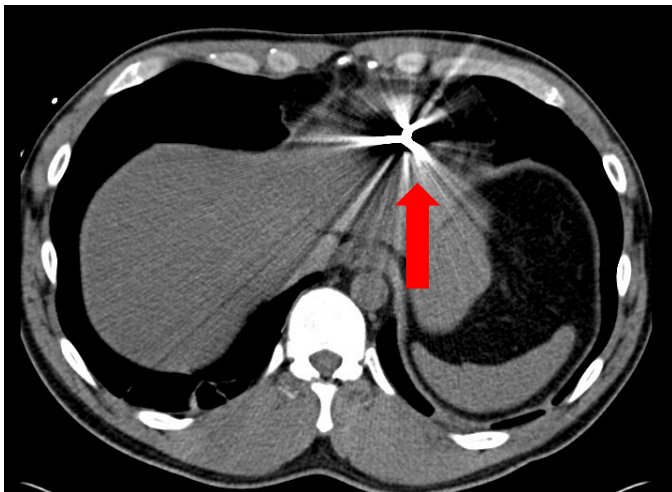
CT Angiogram displaying retained metallic radiopacity within the inferior right ventricle and/or inferior right ventricle myocardium
